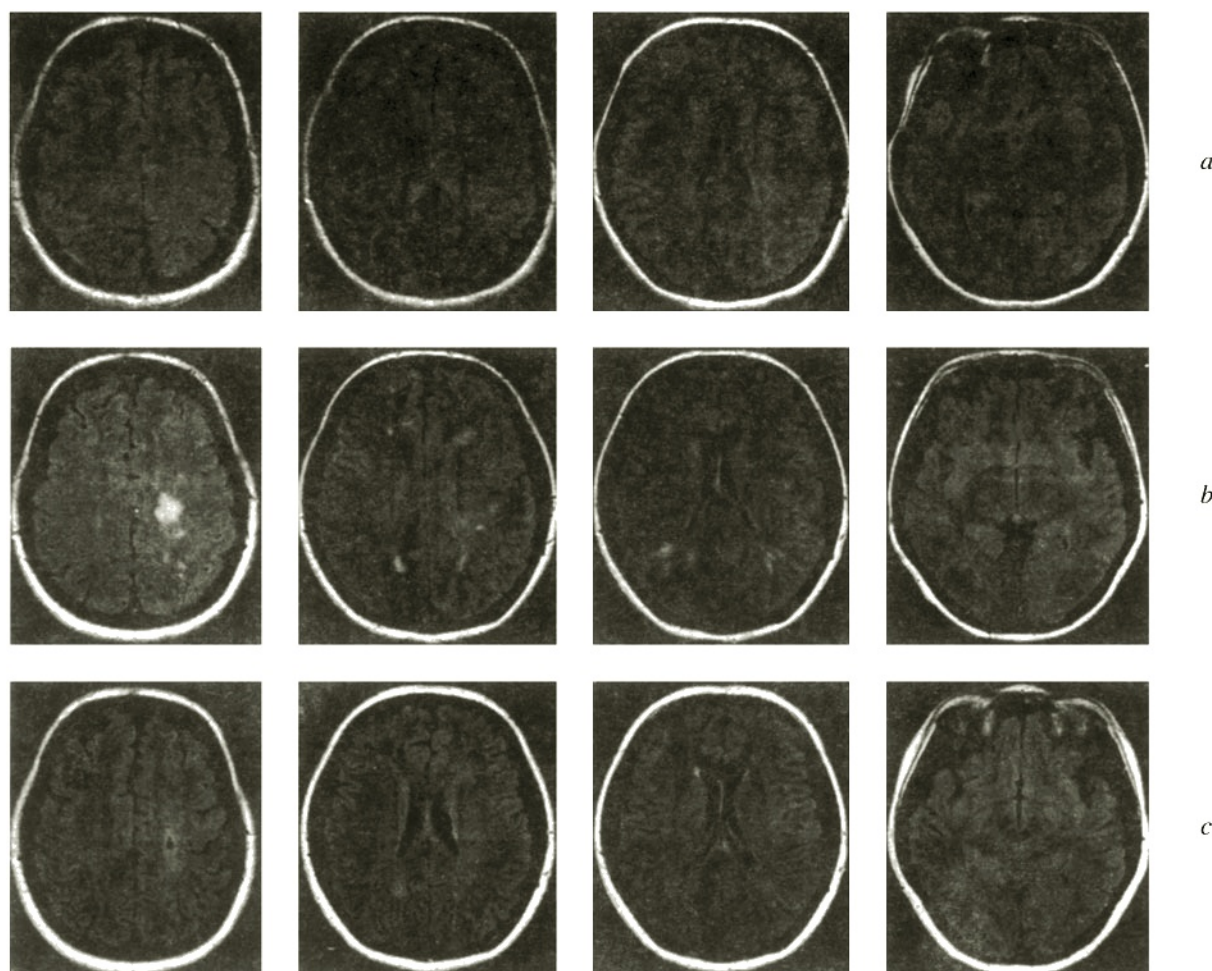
Brain MRI scans, patient S, with diagnosis of “postinfectious acute disseminated encephalomyelitis.” Sequence of images in the axial projection in the FLAIR regime: *a*) December 31, 2009 – minor increase in signal and smoothing of the gyri of the cortex of the insula of the left temporal lobe; *b*) January 24, 2010 – foci of hyperintense signal in the white matter of the frontal and parietal lobes, right temporal-occipital area; *c*) April 22, 2010 – regression of most foci, cystic-gliotic transformation of foci in the white matter of the left frontal lobe at the supraventricular level.
